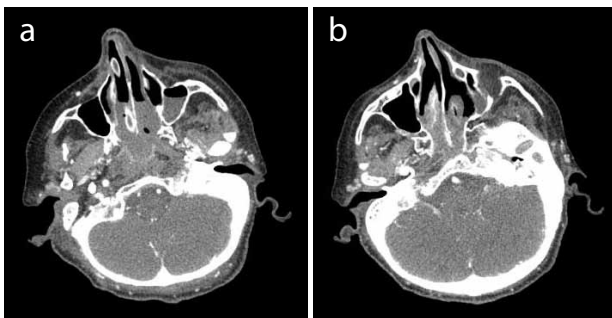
A brain CT showing blurred bony structures of the floor of the mouth and the tongue, consolidation of left maxillary sinus and accompanying invasion of the maxillary bone.
